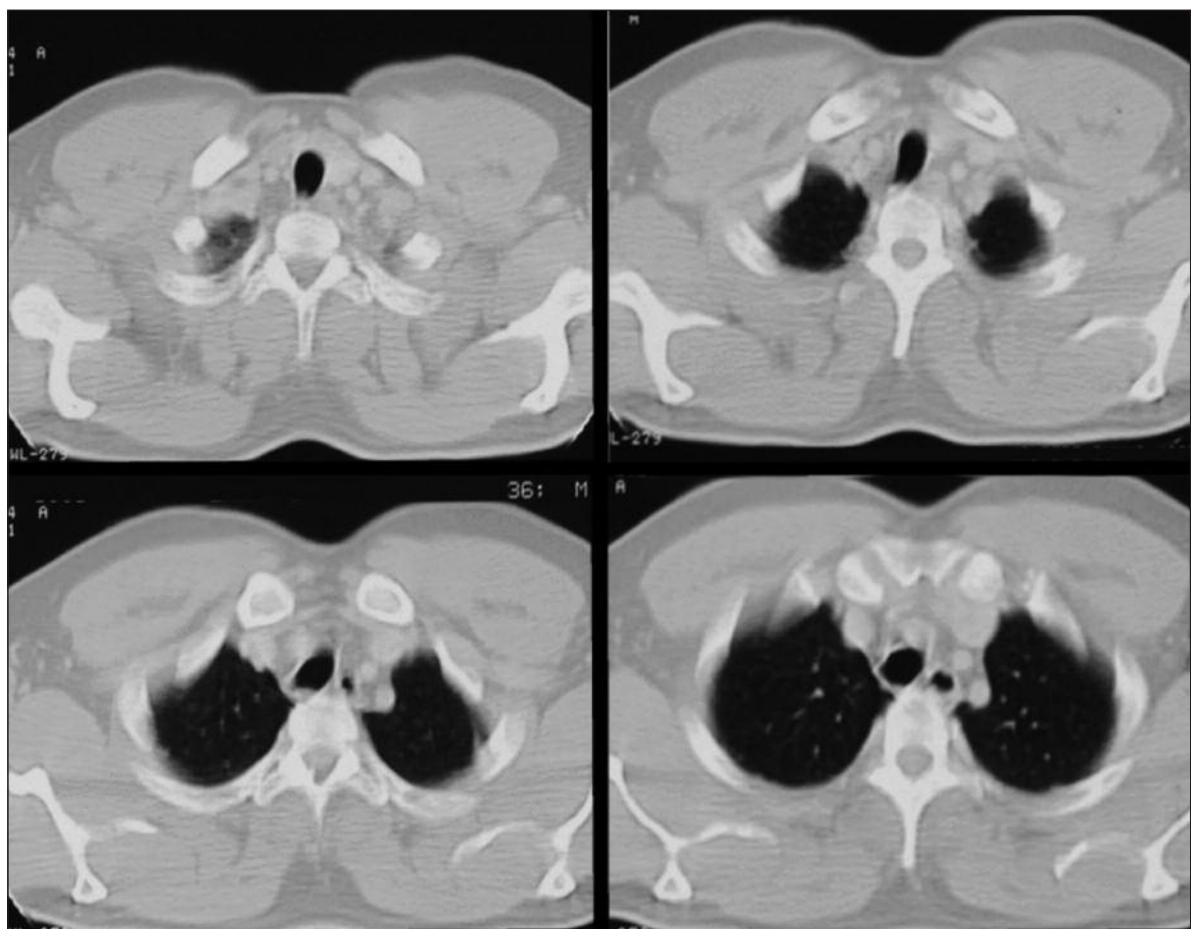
Chest computed tomography scan after 3 weeks.
